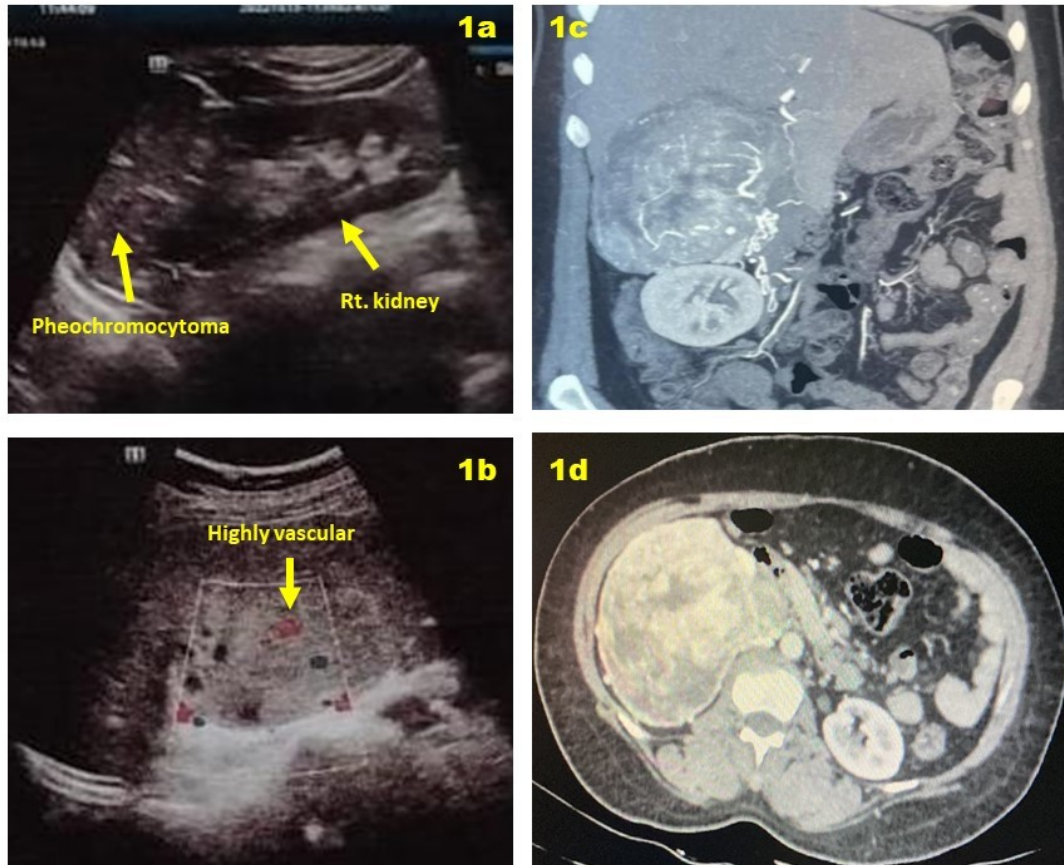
a & b: Ultrasonography shows Rt. Kidney being pushed inferiorly by the adrenal mass. The mass appears to be highly vascular on colour doppler. c & d: CT scan of the abdomen shows Rt. Sided adrenal mass is 12x9.5 cm, pushing the Rt. Kidney inferiorly.
